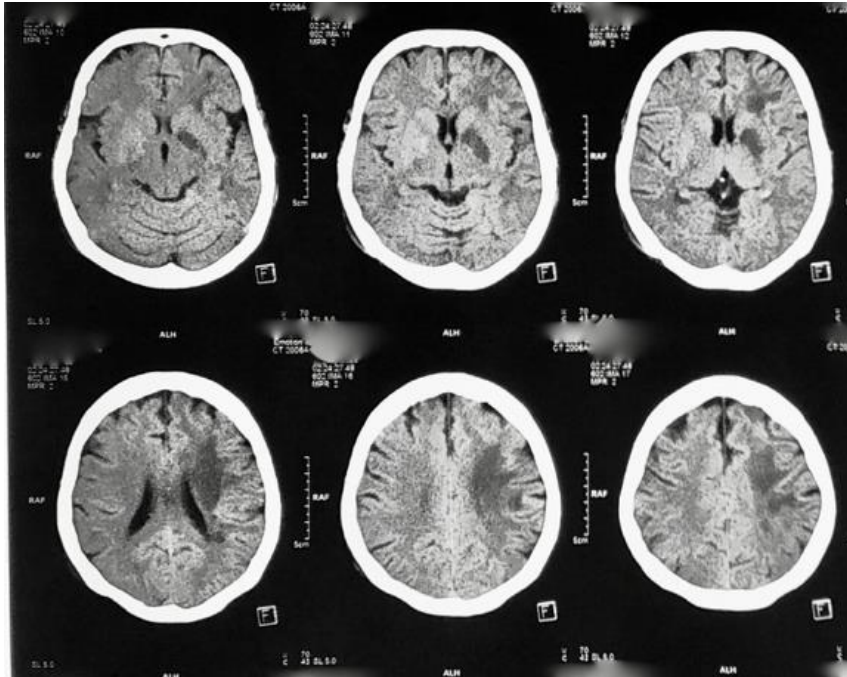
Cerebral infarction on computed tomography scan.
